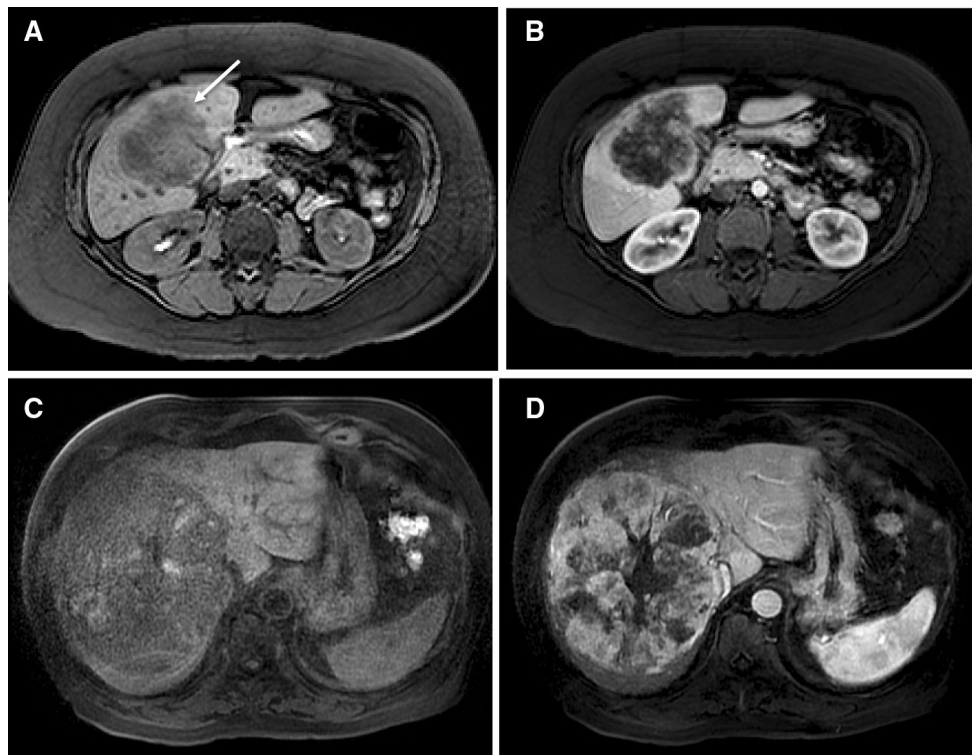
Hypo- versus hyperenhancement. The axial fat-suppressed T1-weighted precontrast image a shows a hypointense liver lesion (arrow) representing a cholangiocarcinoma, which has minimal enhancement following contrast administration on the arterial phase postcontrast image (b). The axial fat-suppressed T1-weighted image
